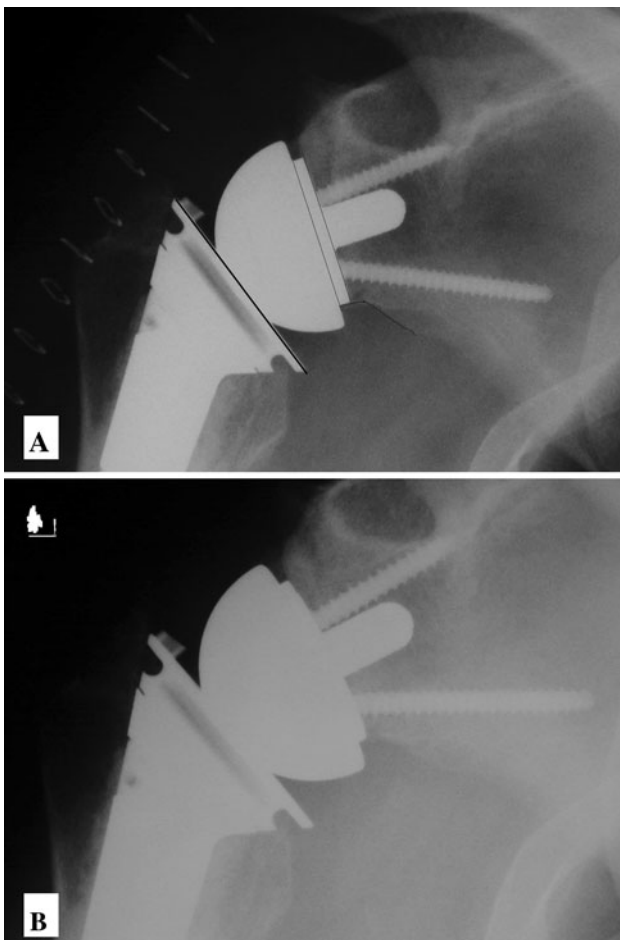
B (A) An immediate postoperative AP radiograph shows a TSA using the Trabecular Metal™ Reverse Shoulder System implanted into the right shoulder for treatment of rotator cuff tear arthropathy. Implant design characteristics of the differing neck-shaft angle (thick black line) and the 3-mm Trabecular Metal™ pad on the back of the baseplate (thin parallel lines) to provide a small offset are seen. These characteristics coupled with inferior placement of the glenosphere (thin curved line on scapular pillar) with an inferior tilt help minimize the potential for postoperative scapular notching. (B) An AP radiograph of the same patient at 2 years of followup shows no evidence of scapular notching.
